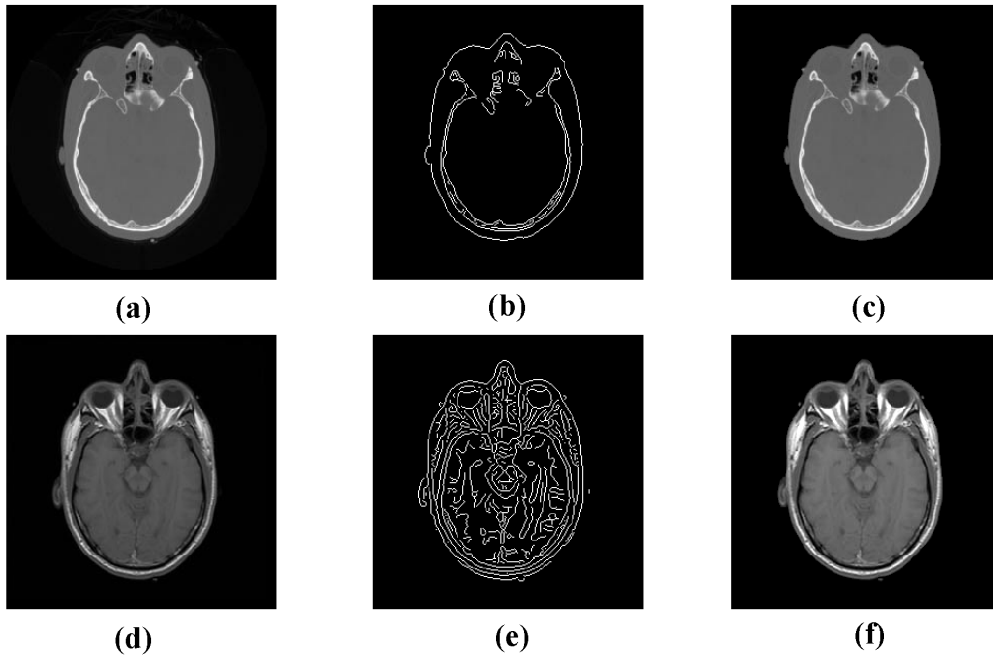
(a), (d) Original CT or MRI image. (b), (e) Edge profile extracted from CT or MRI image. (c), (f) Pre-denoised CT or MRI image based on the edge profiles
